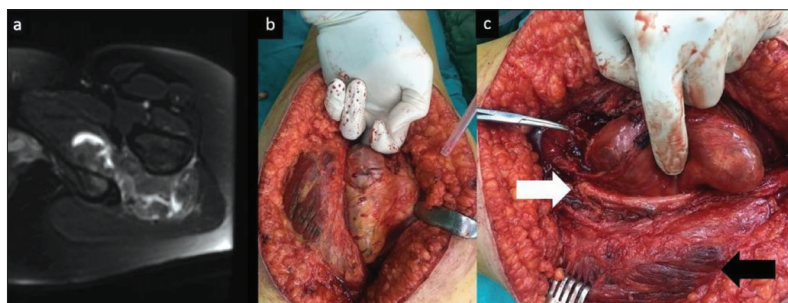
Case 10: a 36-year-old female with tenosynovial giant cell tumor; a – magnetic resonance imaging demonstrated a 10 × 5 × 20 cm nondestructive lesion; b – wide excision was performed using infragluteal approach; c – intraoperative view shows the close proximity of tumor to sciatic nerve (white arrow: sciatic nerve black arrow: gluteus maximus)
